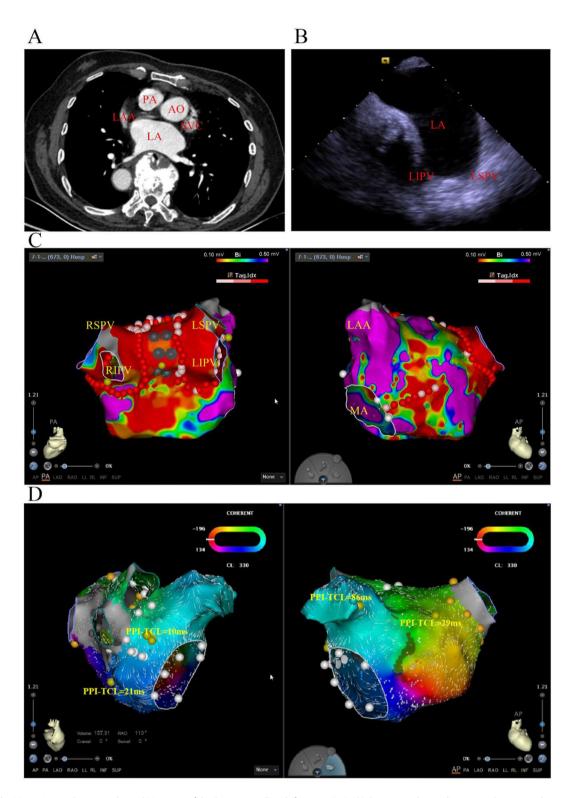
The Mirror-Image Dextrocardia and Mapping of the Recurrent AFL in left atrium (LA). (A) Contrast-enhanced computed tomography examination: Confirmed the patient's rare mirror-image dextrocardia anatomy. (B) Intracardiac echocardiography ruled out intracardiac thrombus and revealed severe compression of the left atrium, increasing the difficulty of ablation. (C) PVI and additional linear ablation was performed during the index radiofrequency ablation procedure (CARTO). (D) Entrainment mapping within the LAA and at three different sites in LA. PA = pulmonary artery, AO = aorta, LA = left atrium, SVC = superior vena cava, LAA = left atrial appendage, LIPV = left inferior pulmonary vein, RIPV = right inferior pulmonary vein, RSPV = right superior pulmonary vein, MA = mitral annulus
